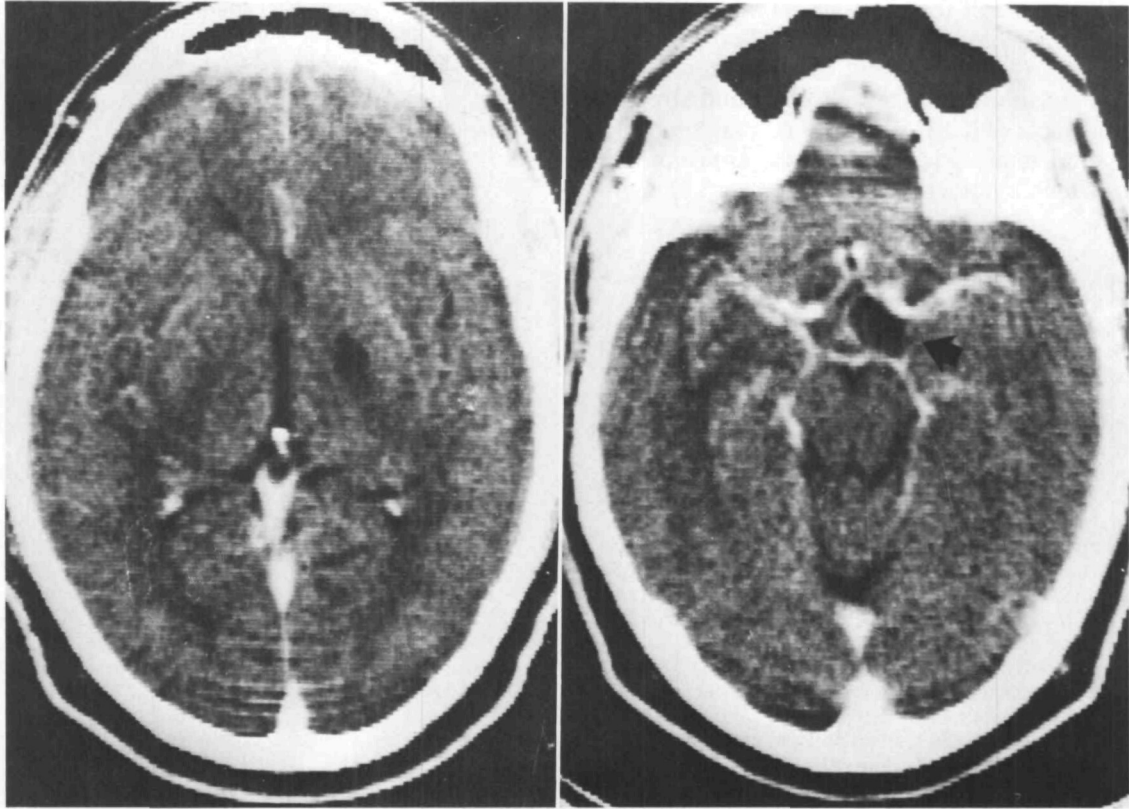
Contrast-enhanced computed tomogram showing (left) small infarction in posterior limb of left internal capsule and (right) cystic suprasellar lesion consistent with cysticercus (arrow).
